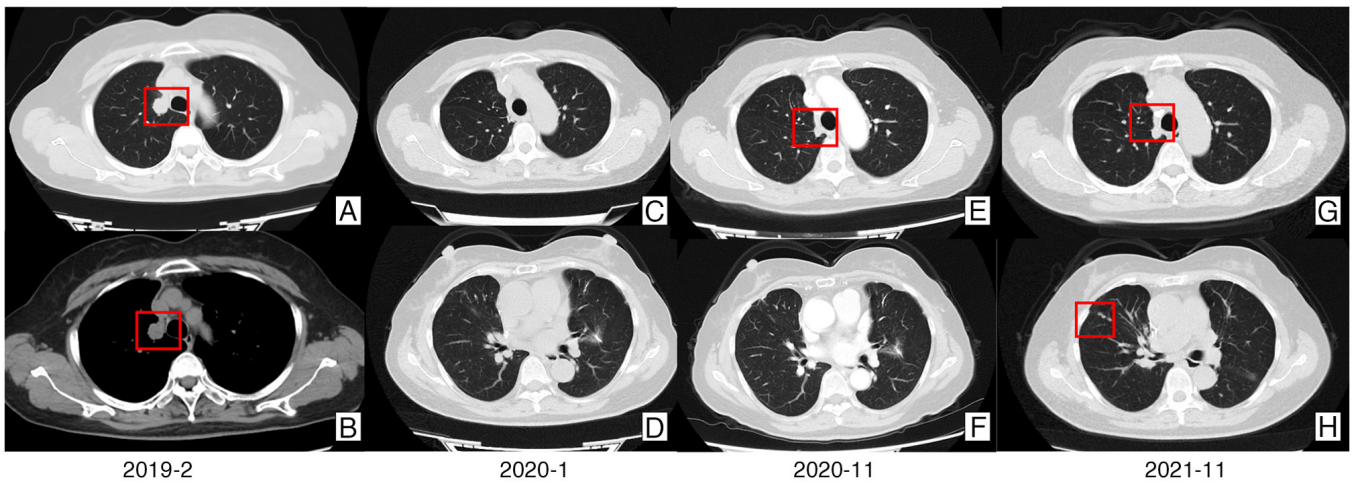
Changes in chest computed tomography during treatment.
